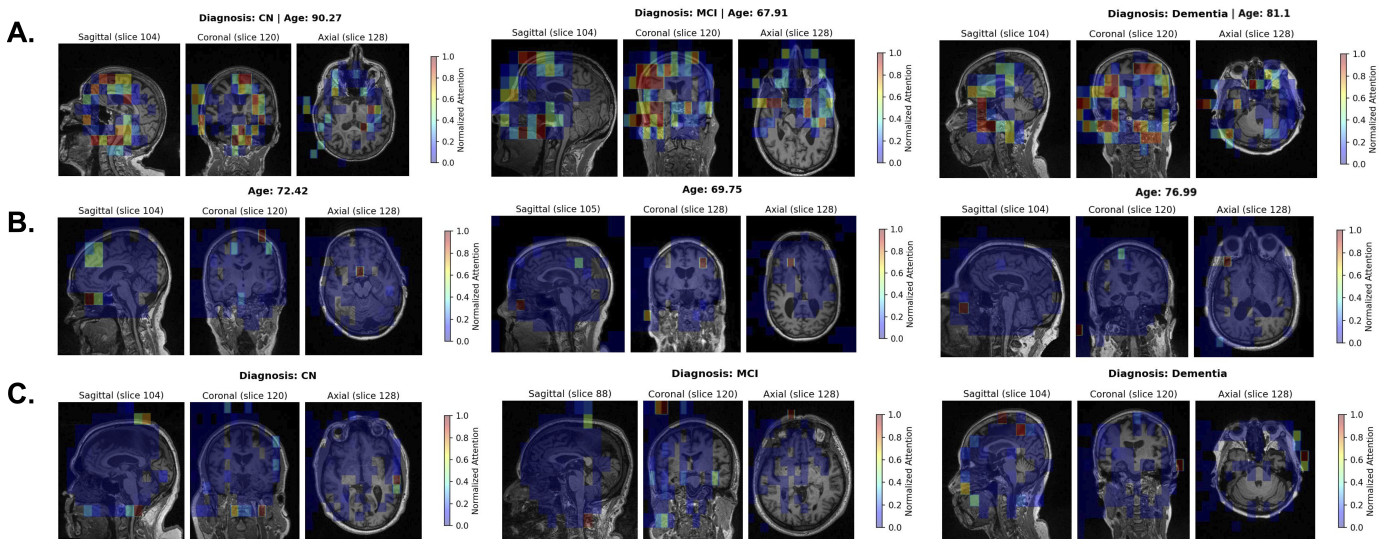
Generated attention maps overlaid on MRI slices from A) Dual sequential classification-regression task, B) Regression task only, C) Classification task only.
